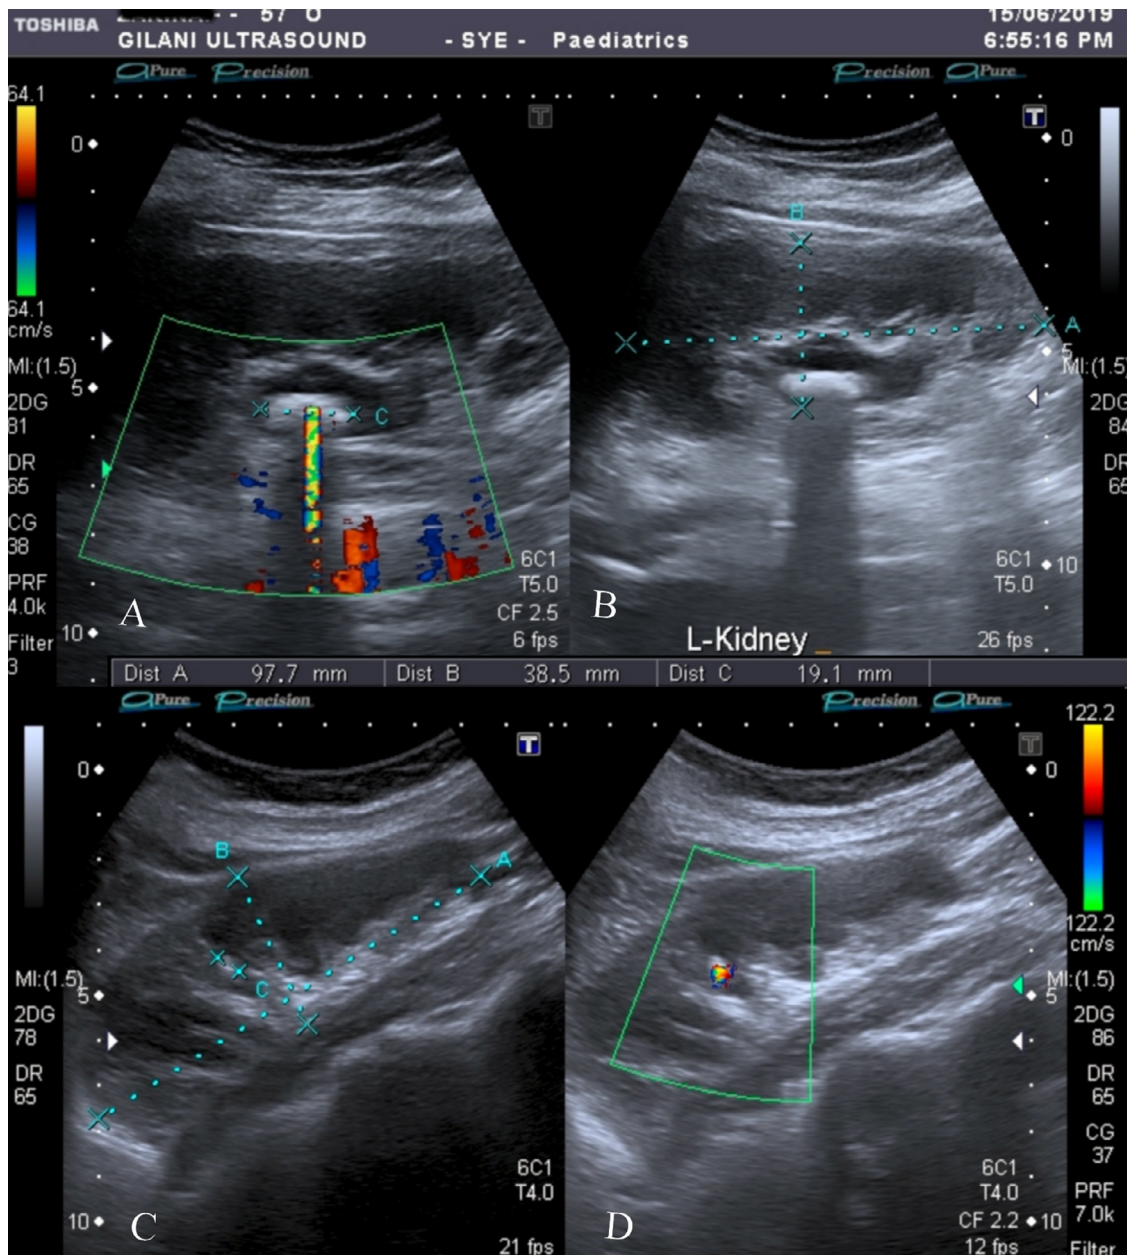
(a) and (b) are images of the same kidney with and without color Doppler twinkling artifact. This stone has a prominent acoustic shadow because it is large. But (c) and (d) are images in the same kidney of a stone with no acoustic shadow (c), but color Doppler twinkling artifact is present (d).
